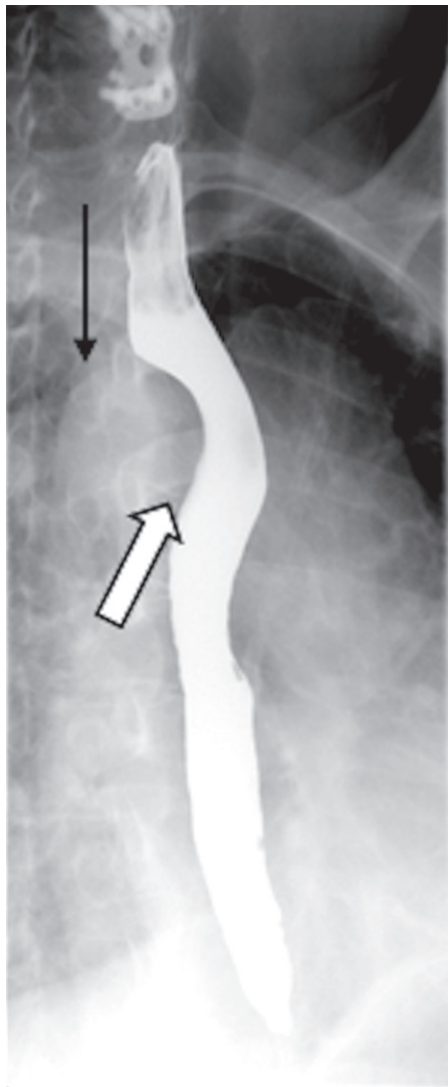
Upright left posterior oblique double-contrast UGI image obtained during the initial swallow in a 65-year-old man with dysphagia. There is a right-sided aortic arch (black arrow), as well as an abnormal impression on the posterior aspect of the esophagus. The findings are strongly suggestive of an aberrant left subclavian artery (white arrow), which was subsequently confirmed with CT (not shown).
